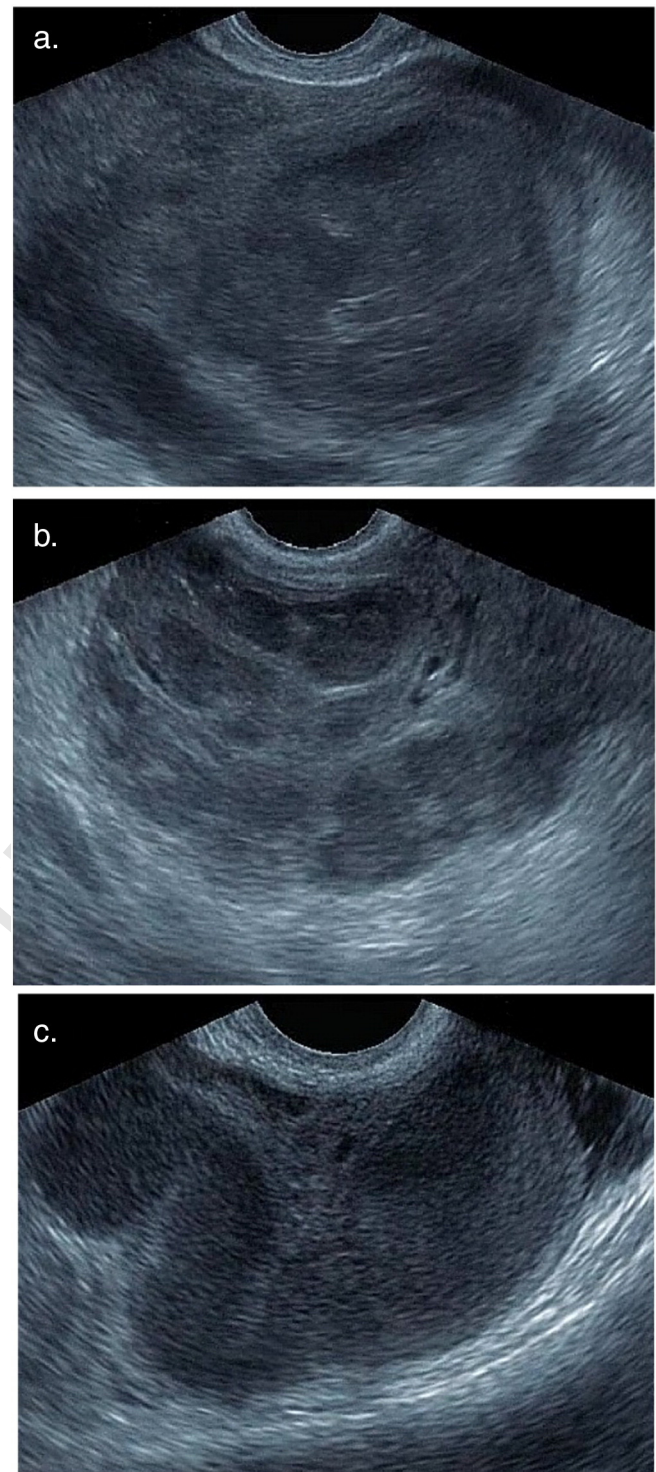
Examples of tubo-ovarian abscess ultrasonographic morphology. Unilocular cystic structure (a). Complex multicystic structure with thick walls and septation (b). Pyosalpinx (cystic structure with incomplete septation) (c).
